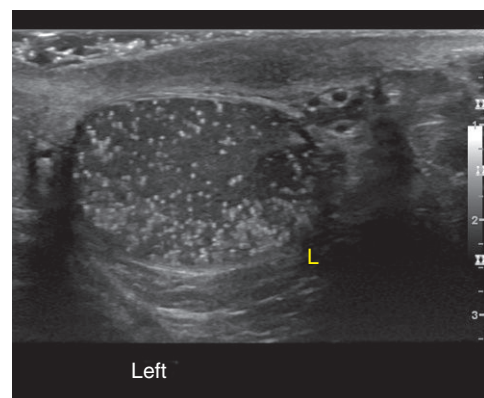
Ultrasound of the left (L) testis shows multiple echogenic foci scattered throughout the testis.
